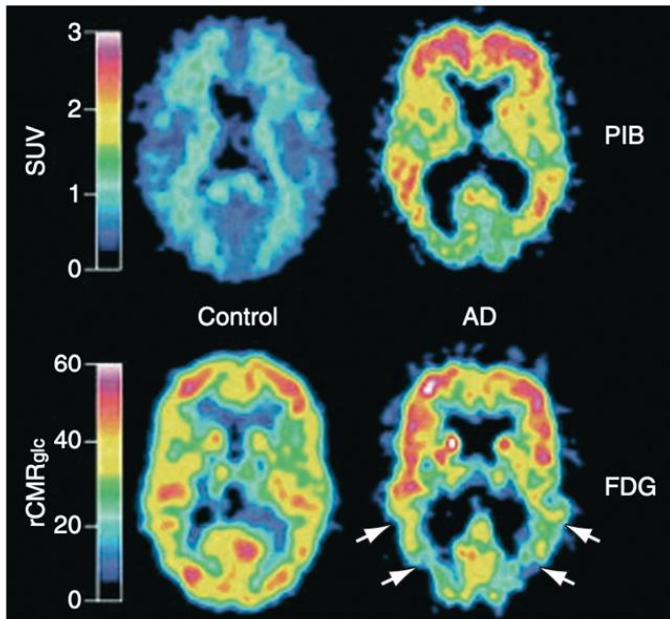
FDG-PET image of a normal and an Alzheimer's patient demonstrates significantly reduced metabolism in the temporo-parietal cortex and normal metabolism in the frontal region.
